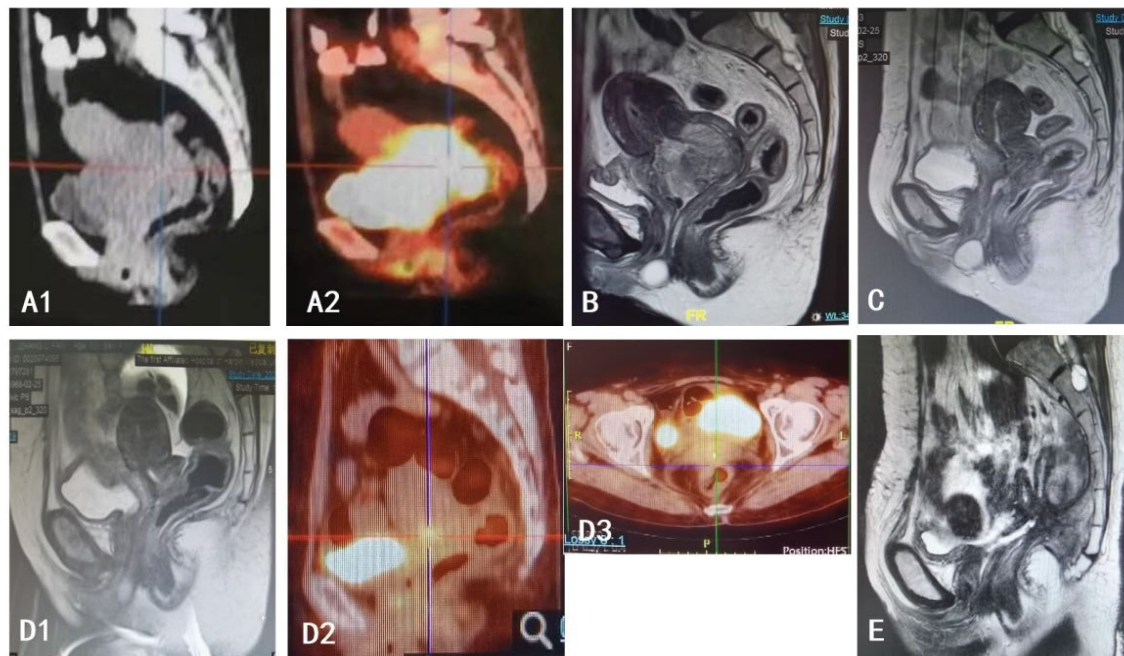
Pelvic PET-CT and MRI images obtained during the treatment course. The whole body PET-CT examination at the initial diagnosis showed a mass in the cervix measuring $8.9 \times 9.7 \times 6.5$ cm. (A1) The corresponding CT image is shown, while (A2) shows the PET-CT image, which indicated an abnormally high uptake of ^{18}F -FDG with a maximum standard uptake value (SUV) of 14.5. Following radical radiotherapy and chemotherapy, a pelvic Magnetic Resonance Imaging (MRI) displayed a high signal mass located at the cervix of the T2-weighted MRI image. The signal was not homogeneous, with a size of approximately $6.6 \times 5.7 \times 4.2$ cm, and the border of the uterine body was indistinct. After Camrelizumab + apatinib treatment, patient reached complete response which indicated in Pelvic MRI. Pelvic MRI: T2-weighted MRI showed irregular uterine cervical morphology, the solid mass was not found, but there were patchy slightly high T2 signal shadows, and the cervical matrix was poorly displayed. (D) Preoperative pelvic MRI, (D1) T2-weighted MRI showed irregular uterine cervical morphology, with patchy slightly elongated T2 signal shadows in the posterior lip of the cervical canal. The T2 signal band in the posterior lip of the cervical canal matrix was poorly displayed. The boundary between the upper posterior wall of the cervix-vagina and the anterior wall of the rectum was unclear, with a loss of fat space in between, and the local signal of the rectal mucosa was uneven, suggestive of possible rectal invasion or adhesion. (D2) PET-CT showed focal increased ^{18}F -FDG uptake in the cervical area, with SUVmax of 4.9, and the lesion size was approximately $1.4 \text{ cm} \times 1.2 \text{ cm}$. (D3) PET-CT showed adhesion between the cervix and rectum, with unclear demarcation, without accompanying increased ^{18}F -FDG uptake. (E) Postoperative pelvic MRI: T2-weighted images showed absence of uterine adnexa, residual lower rectum was observed, and no sigmoid colon structure was seen.
